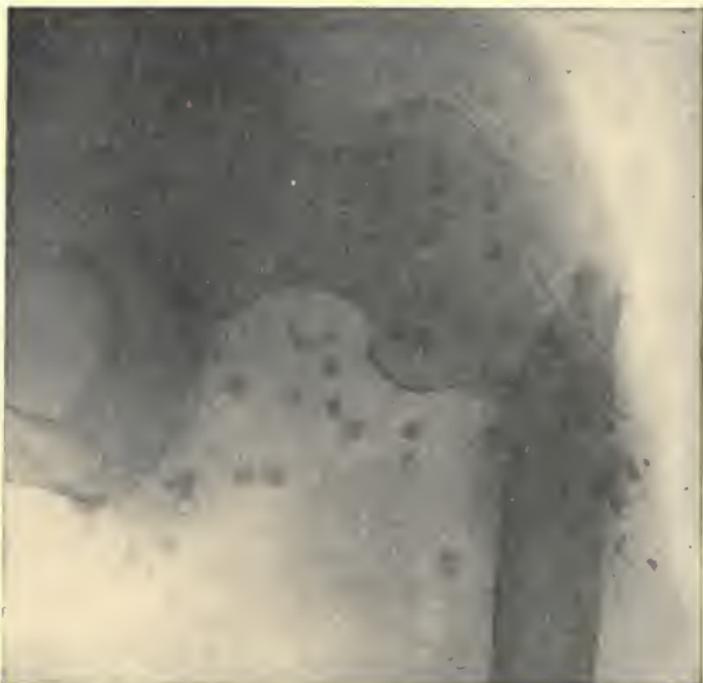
X-ray showing the effect of bird-shot. (Kindness of Dr. G. D. Stewart.)
